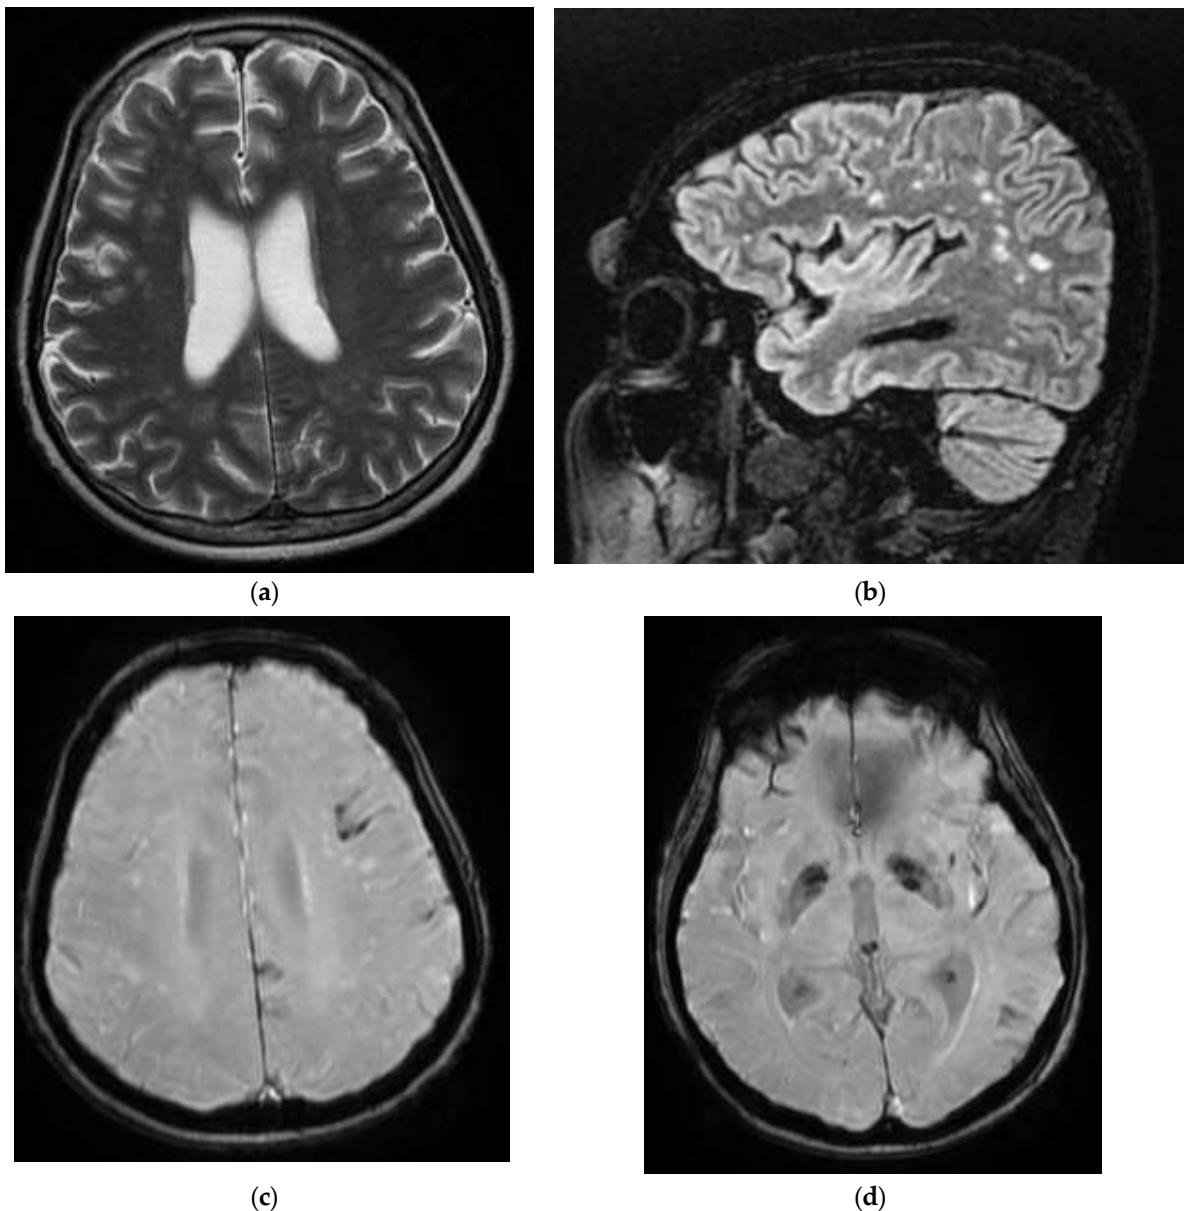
MRI images of the Case 3 patient reveal multiple centimetric lesions in T2/FLAIR hyper-signal (a,b), with no diffusion restriction, disposed in a white hemispheric substance in the bilateral subcortical frontal–temporal–parietal area, as well as in the right cerebellar hemisphere, and supratentorial demyelinating lesions most probably with an ischemic vascular sublayer. Additionally, linear and curvilinear traces in SWAN signal (c,d), disposed in the left cortical parietal, frontal area–frontal cortical and left parietal hemosiderosis.
